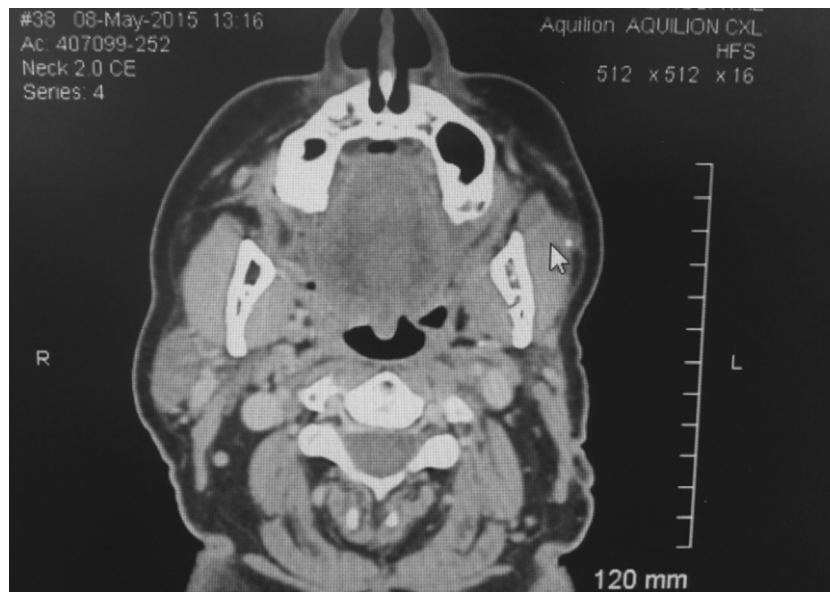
CT image of parotid stone.
